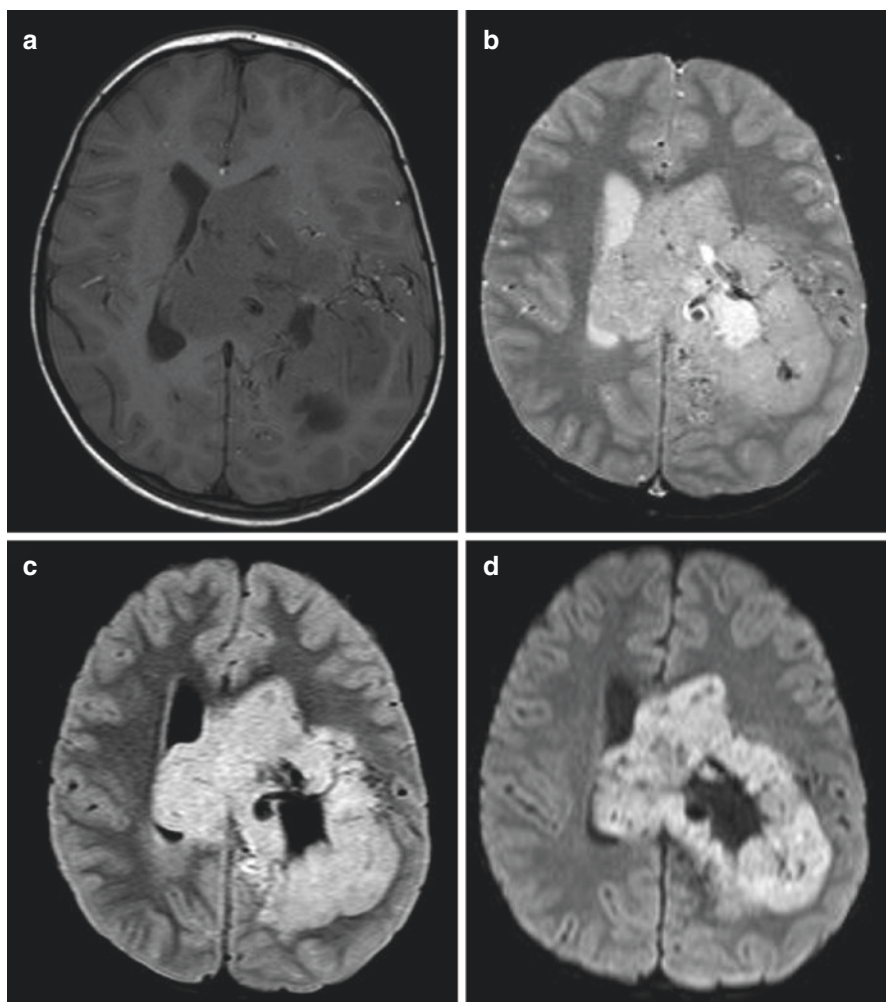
Representative axial images from MRI of a 4-year-old patient with SPNET. On non-contrast T1-weighted (a), T2-weighted (b), and fluid-attenuated inversion recovery (FLAIR, c) images, tumor has isointense signal equivalent to normal gray matter, whereas the tumor demonstrates abnormal diffusion restriction on diffusion-weighted imaging (DWI, d) due to high cellularity of the tumor. Note characteristic absence of associated vasogenic edema on T2-weighted and FLAIR images
